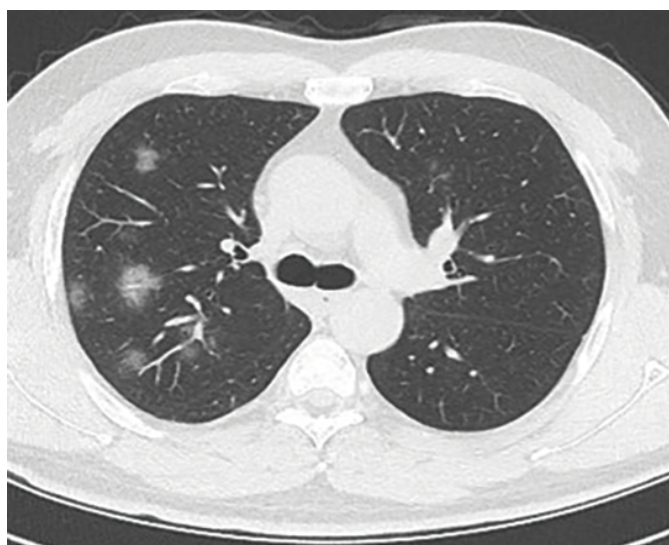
Lung CT image of a 40-year-old COVID-19 male patient. Peripheral predominant patchy ground-glass infiltrations
